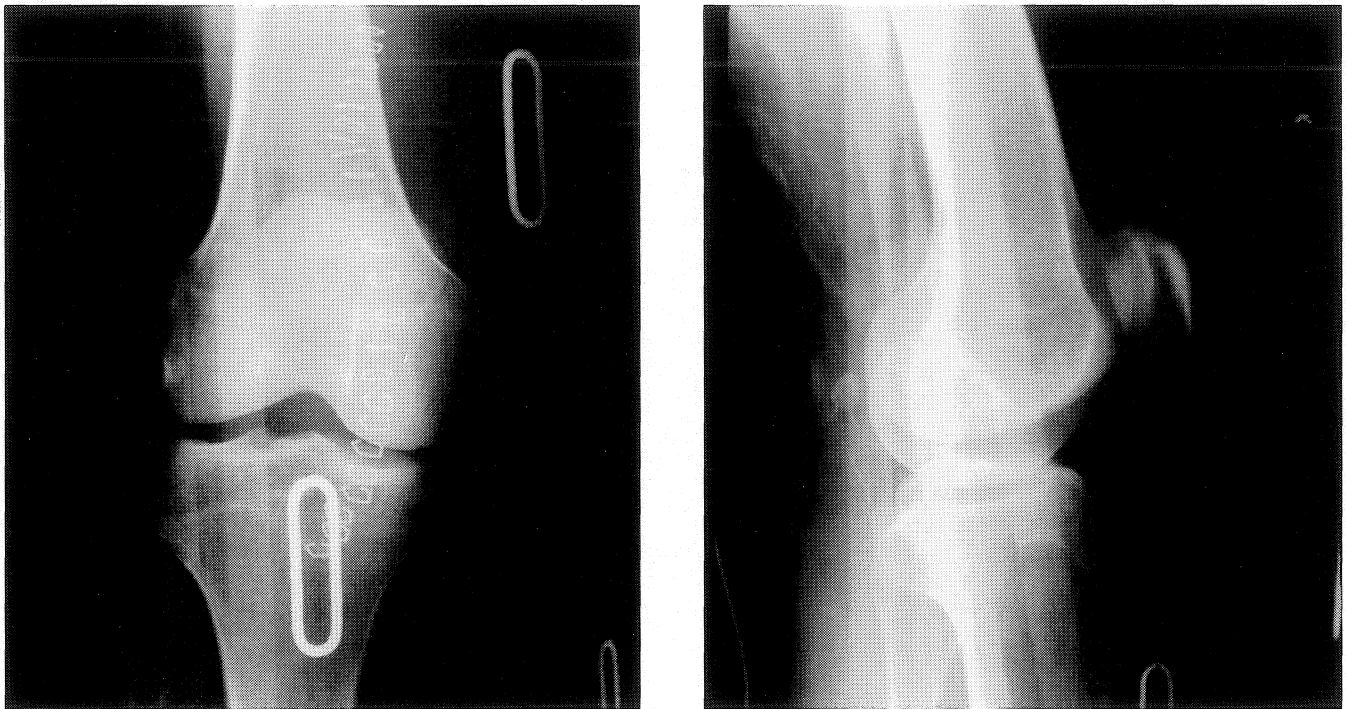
AP (A) and lateral (B) radiographs of the left knee postoperatively.
